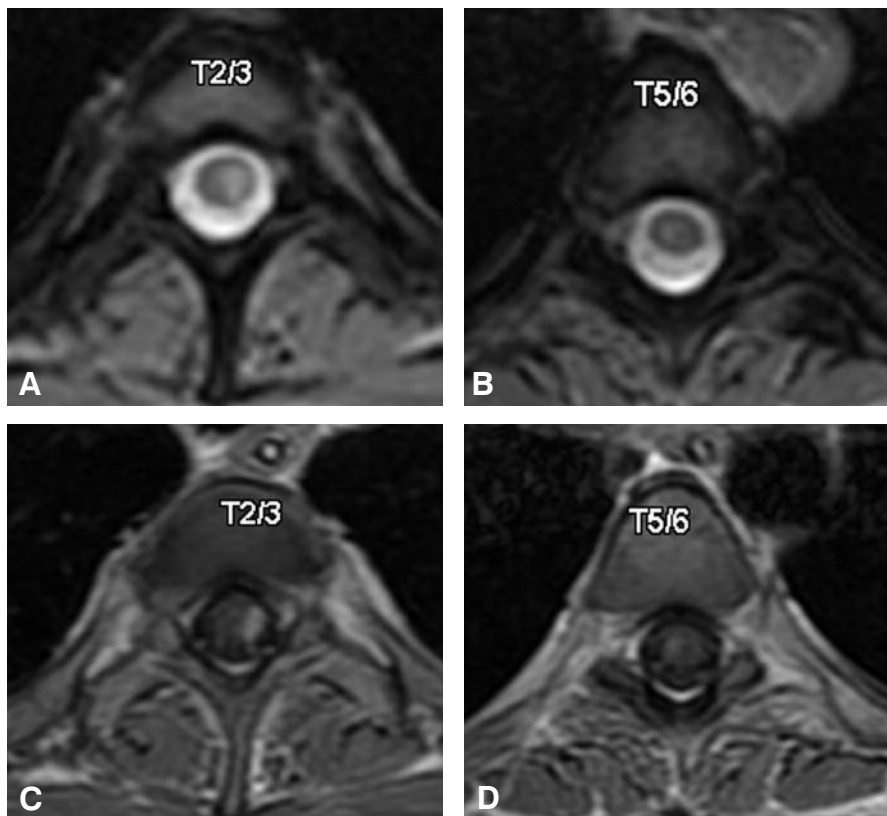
(A and B) Axial T2-gradient echo MR images of lesions at T2-3 and T5-6 and (C and D) axial T1-gradient echo MR images with contrast of the same lesions show contrast-enhancing demyelinating lesions.
